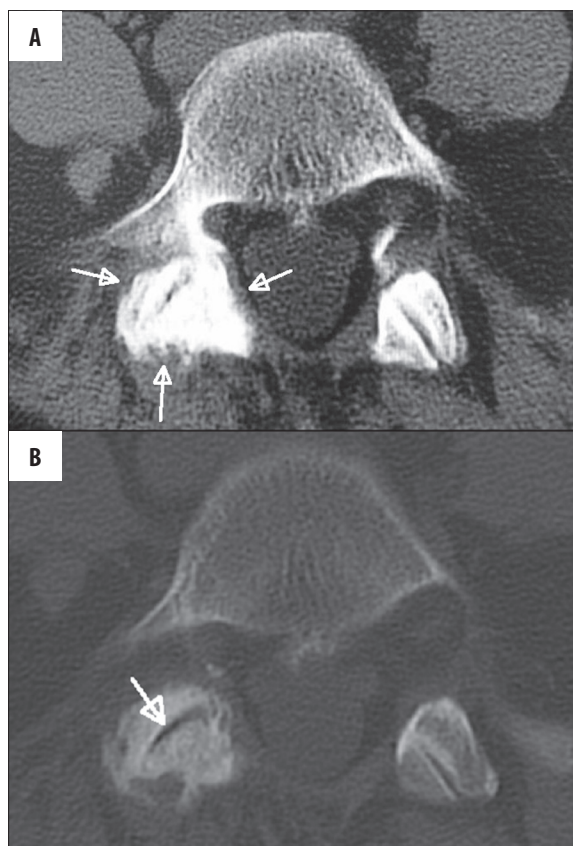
Computed tomography of the spine. (A) soft-tissue window, blurred outline and increased density of paraspinal soft tissues in the right L5/S1 facet joint area (arrows). (B) bone window, degenerative-productive changes of the both L5/S1 facet joints, more pronounced on the right side. Vacuum phenomenon in the right facet joint (arrow).
